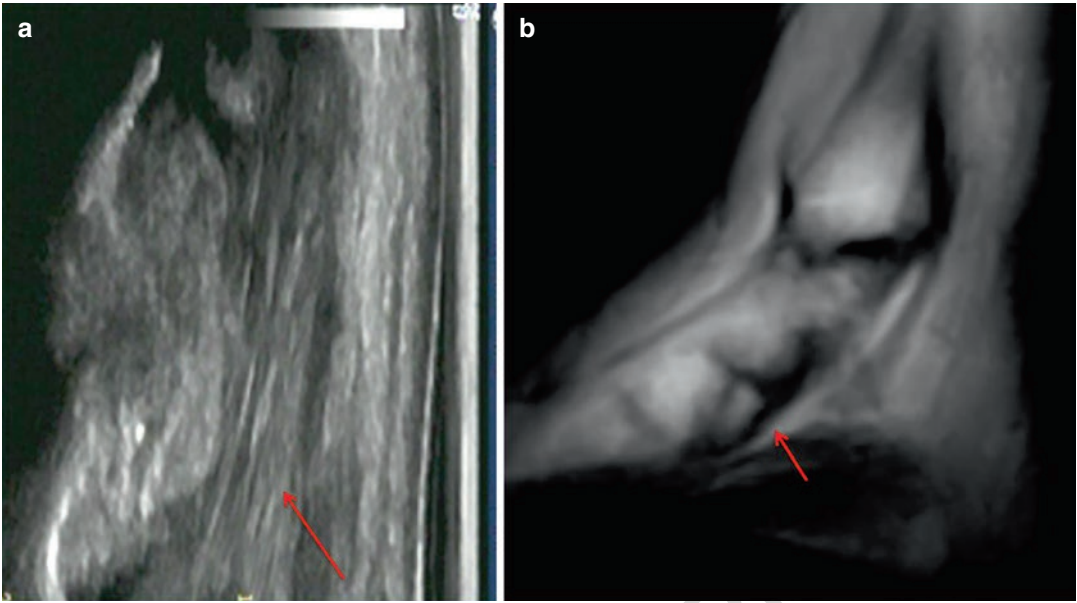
(a, b) Dynamic US and MRI scan depicting an accessory scaphoid bone and tendinopathy affecting the distal insertion of the posterior tibial muscle
